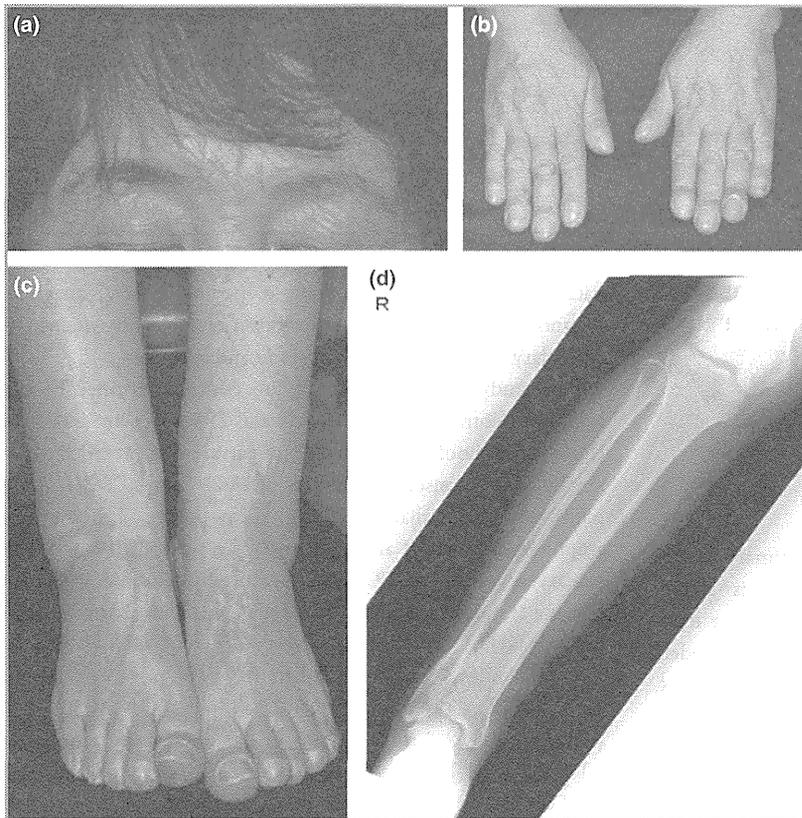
Clinical features including radiograph. (a) The facial appearance of the patient. Furrowing of the forehead and greasiness of facial skin are negligible. (b) Digital clubbing. (c) Clubbing of toes and cylindrical enlargement of the legs. (d) Periosteal hyperostosis of the tibia and fibula.
